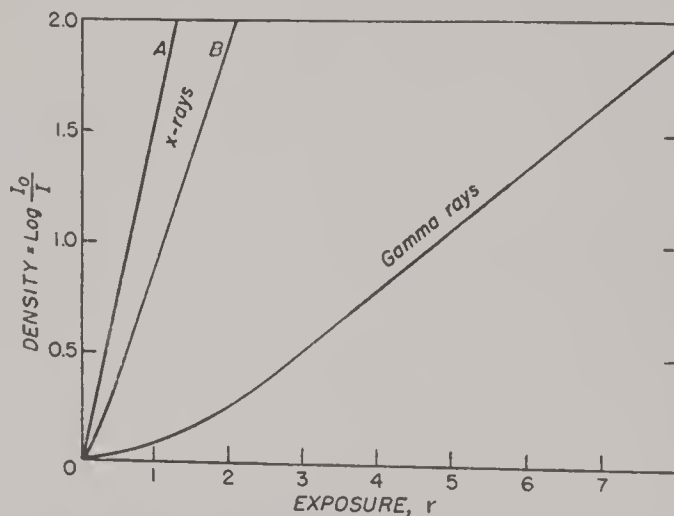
Curves showing the variation in blackening in the same type of film for equal doses of x-rays and gamma rays. A—80 kv. x-rays, no filter, B—200 kv. x-rays, filtered by 2 mm. of copper. Gamma rays filtered by 6.8 mm. of gas.
